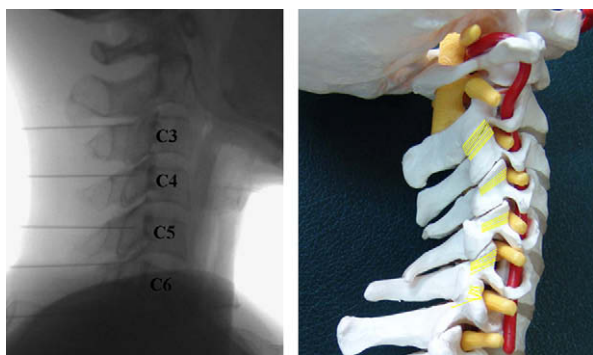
C-arm fluoroscopy after ultrasound-guidance shows that the needle tip for the C5 medial branch is located over the middle portion of the C5 articular pillar, but other medial branches are located progressively higher on their respective articular pillars at levels progressively further away from the C5 level. The needle tip for the C7 medial branch is obscured at the base of the neck, due to overlying shoulder girdles. These locations of needle tips applied to the C3 through C7 medial branch correspond with the distribution of cervical medial branches, which is represented as oblique yellow lines in a cervical model on the basis of International Spine Intervention Society guidelines.
